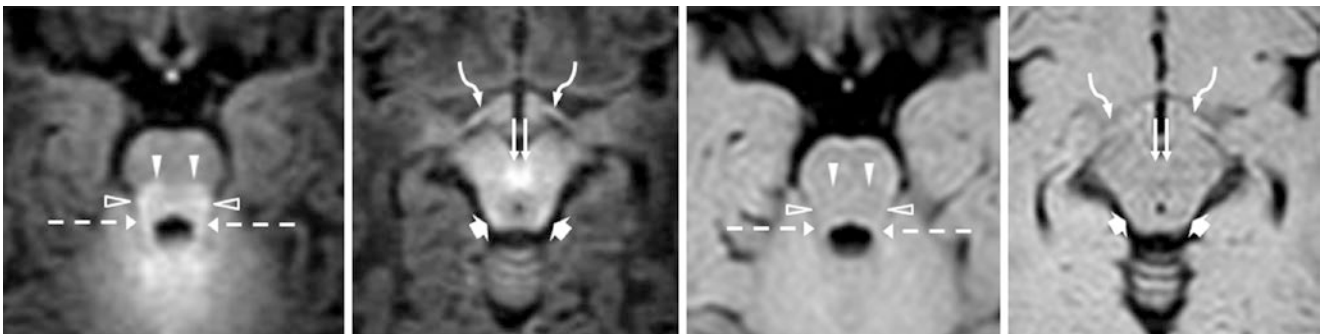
A 17-day-old term neonate had a normal 3T MRI with axial GE T1WIs (left images) and 3D FLAIR (right images). There is T1-bright myelination of the BIC (wide arrows), DSCP (double
